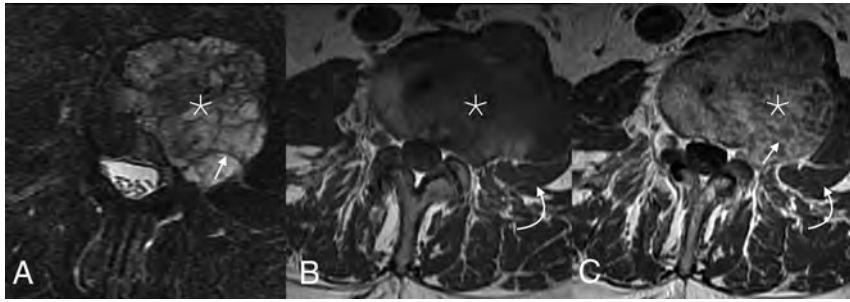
Axial MR imaging of the mass. T2 fat-saturated (A), T1 precontrast (B), and postcontrast (C) sequences show a mass centered within the mid and left aspects of the L3 vertebral body (*asterisk*). Most of the tumor demonstrates substantial T2 prolongation, which is particularly evident with fat saturation. Internal T2-hypointense septations are noted, which enhance with moderate avidity (*straight arrows*), while the fluid-filled regions lack enhancement. The tumor extends out of the left vertebral body into the adjacent soft tissues, displacing but not invading the left psoas muscle laterally (*curved arrows*).
